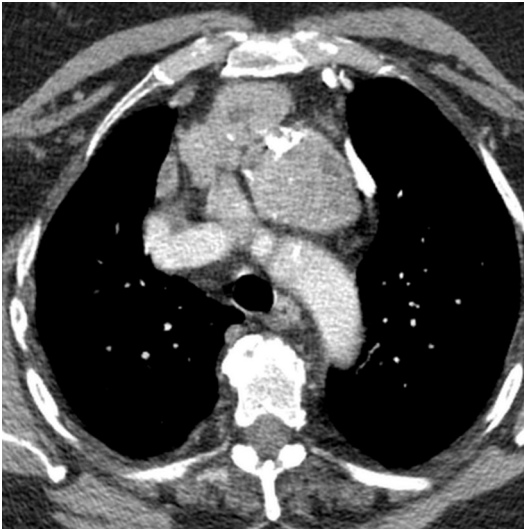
Mediastinal goiter. Contrast-enhanced axial CT shows a large, lobulated, prevascular mediastinal goiter that demonstrates intense and sustained enhancement, cystic changes, and coarse calcifications. Multiplanar imaging (not shown) documented continuity with an enlarged cervical thyroid.
